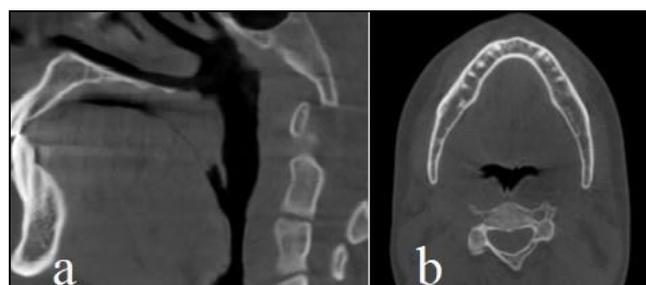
CBCT of an OSA patient demonstrating small upper airway (a. sagittal slice, b. axial slice)
